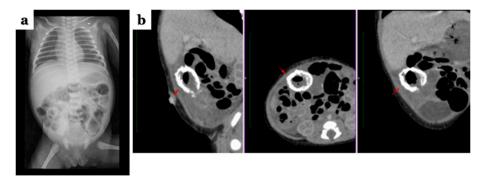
(a) A babygram showed a dilated small and large bowel. (b) An abdominal CT scan revealed a cystic mass with calcifications at the right lumbar region consistent with meconium calcified peritonitis measuring 10 cm.
